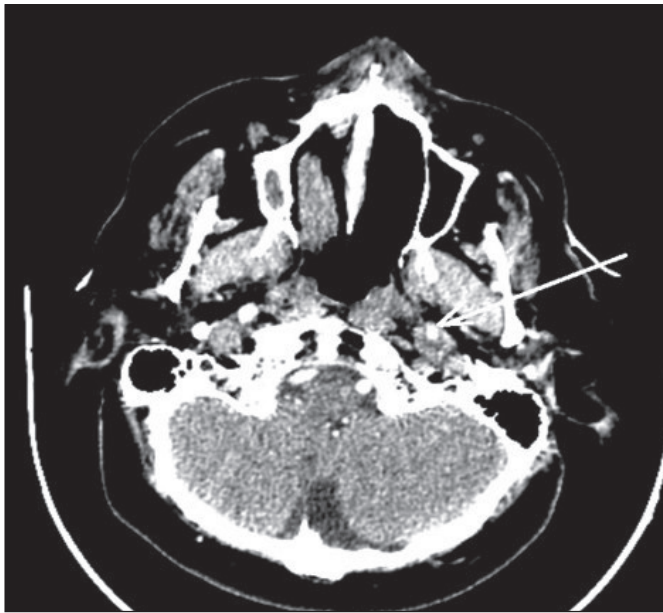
CT without contrast. Emphasizing the increase in size of the ICA due to intramural hematoma and narrowing of the arterial lumen.
